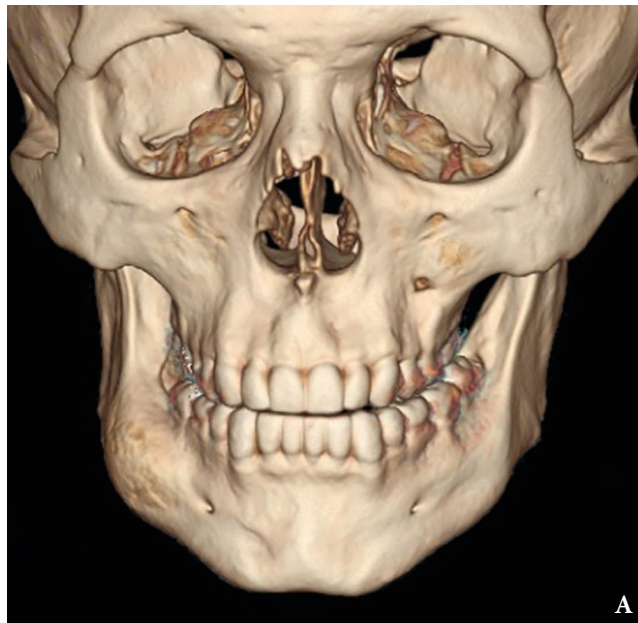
Case 6. A: 3-dimensional CT scan showing buccal cortex expansion without erosion. B: Initial X-ray. C: Lesions' size scheme (*blue*) for resection.
